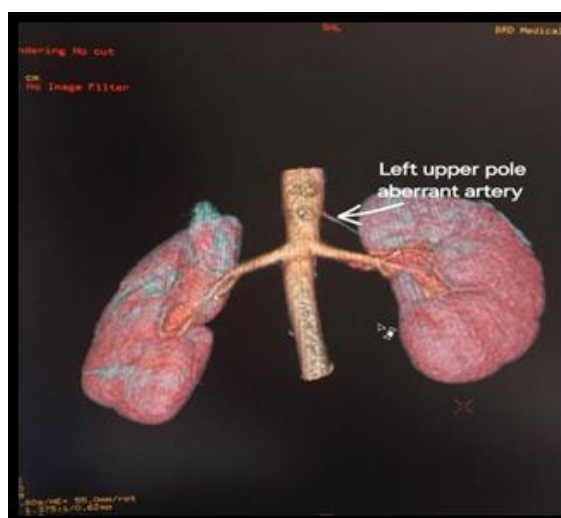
Computed tomography arterial phase images showing left upper pole aberrant renal artery
